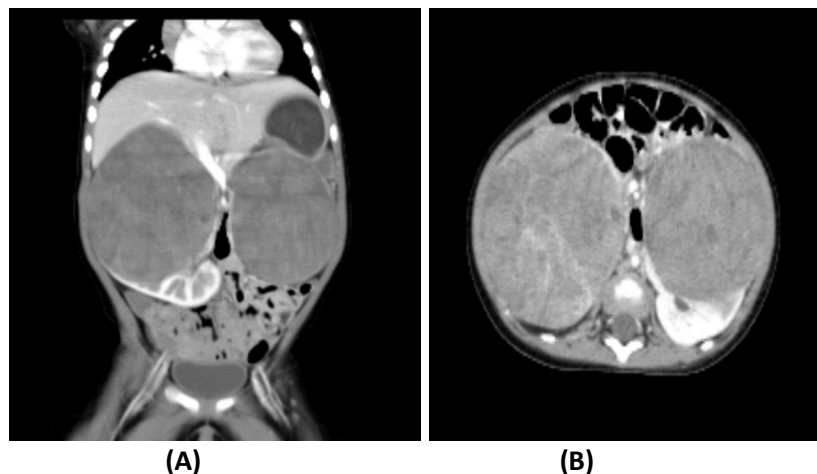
(A) Contrast enhance coronal reformatted CT scan of whole abdomen showing mildly enhancing bilateral renal mass. (B) Contrast enhances axial CT scan of whole abdomen showing mildly enhancing mass involving both kidneys.
